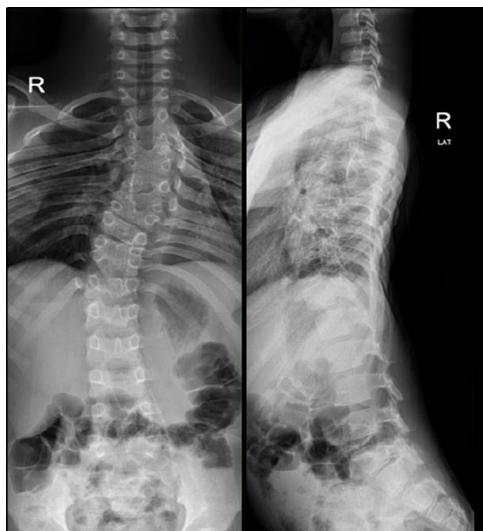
Whole spine radiograph revealing Cobb's angle of 26° and failure of segmentation of multiple thoracic vertebrae.
